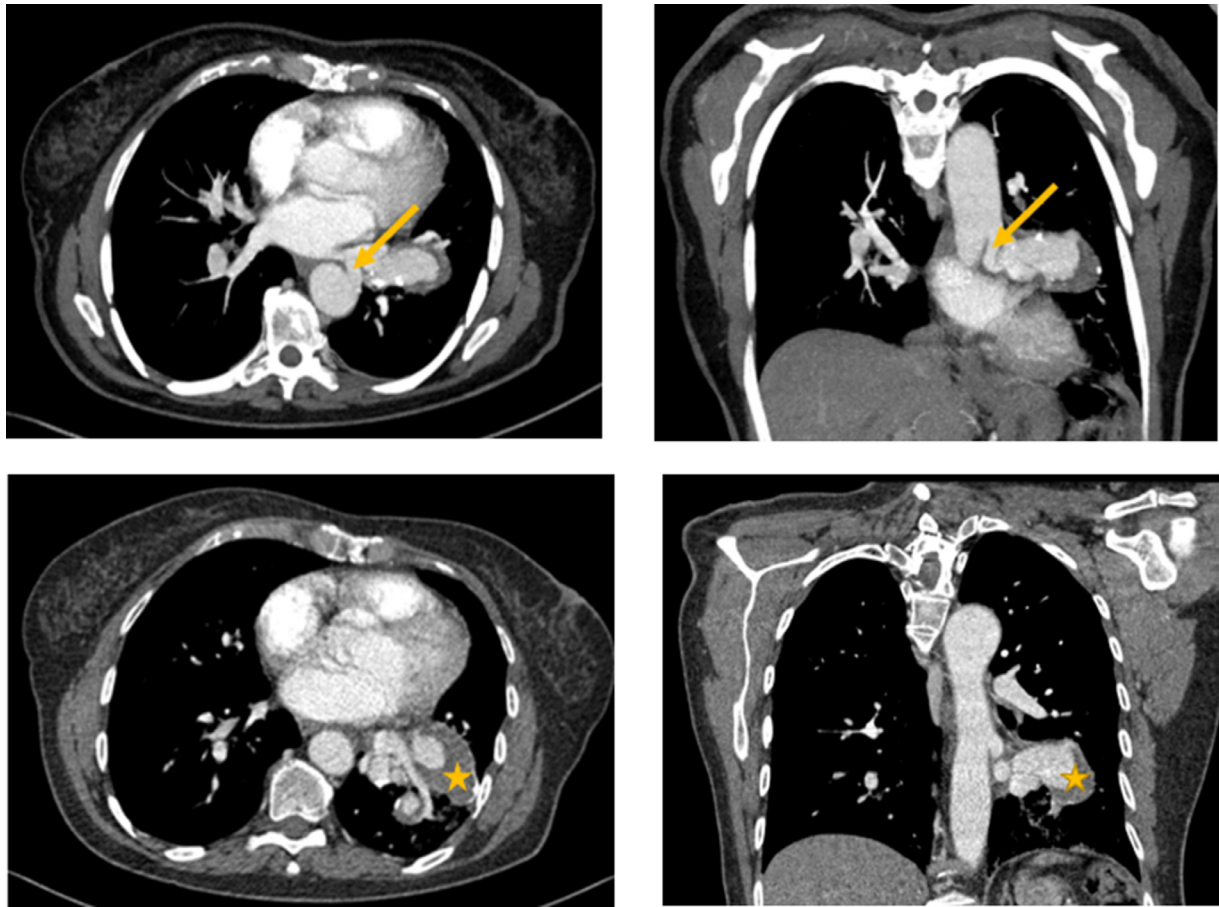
Axial and coronal contrast-enhanced computed tomography (mediastinal window) shows a well-defined left lower lobe heterogeneous mass supplied by a systemic artery (arrow) that arises from the distal descending thoracic aorta with a partially thrombosed aneurysm (star).
